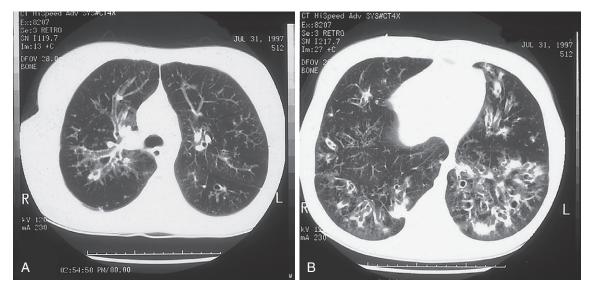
Cystic fibrosis. CT scans of a 19-year-old woman with severe bronchiectasis and cystic fibrosis. Thickened airways are seen in longitudinal section through the upper lobes (A) and in cross-section in an image from the lower lobes (B).
